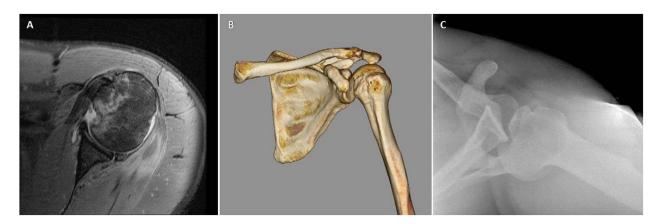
Engaging reverse Hill-Sachs lesion showing marrow edema on the anterior humeral head along with the bony trough. A) MRI. B) 3D CT reconstruction. C) Injury plain film radiograph in posterior dislocated position.
